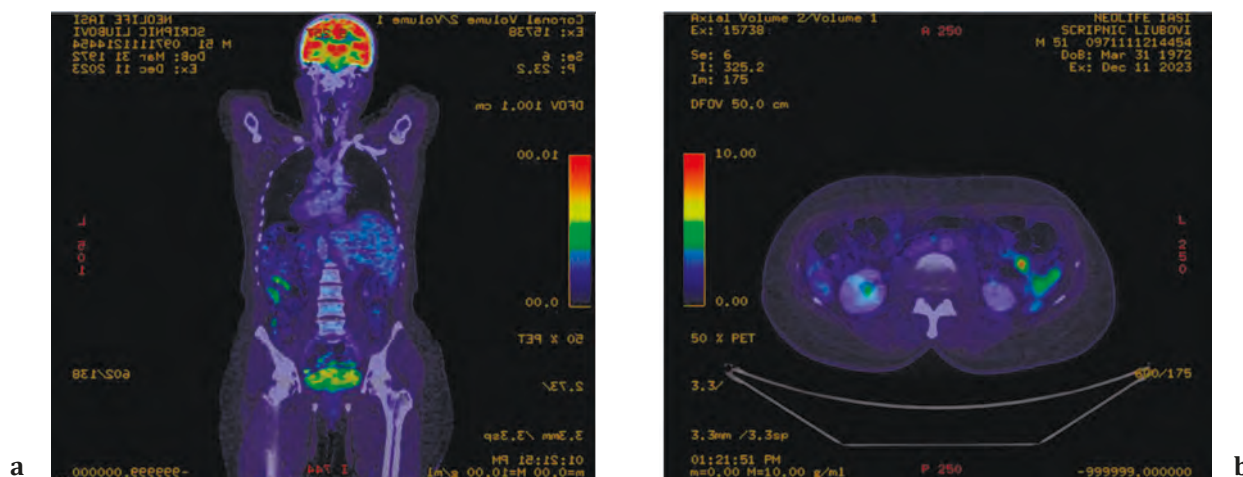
FDG PET-CT reduced accumulation of 18-fluorodeoxyglucose, complete metabolic response. a. sagittal section, b. cross-section
